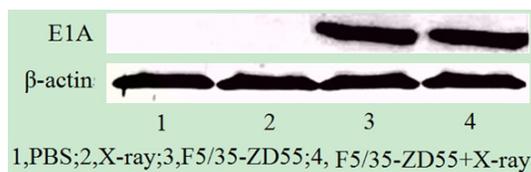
F5/35-ZD55 induced efficient delivery of E1A in renal cell carcinoma cell line Ketr-3 cells. Cells were treated with F5/35-ZD55 or X-ray alone and F5/35-ZD55 along with X-ray. Phosphate-buffered saline (PBS) treatment served as a negative control. After 72 h treatment, E1A protein expression levels were analyzed by western blotting using anti-E1A antibody. β -actin served as a loading control.
